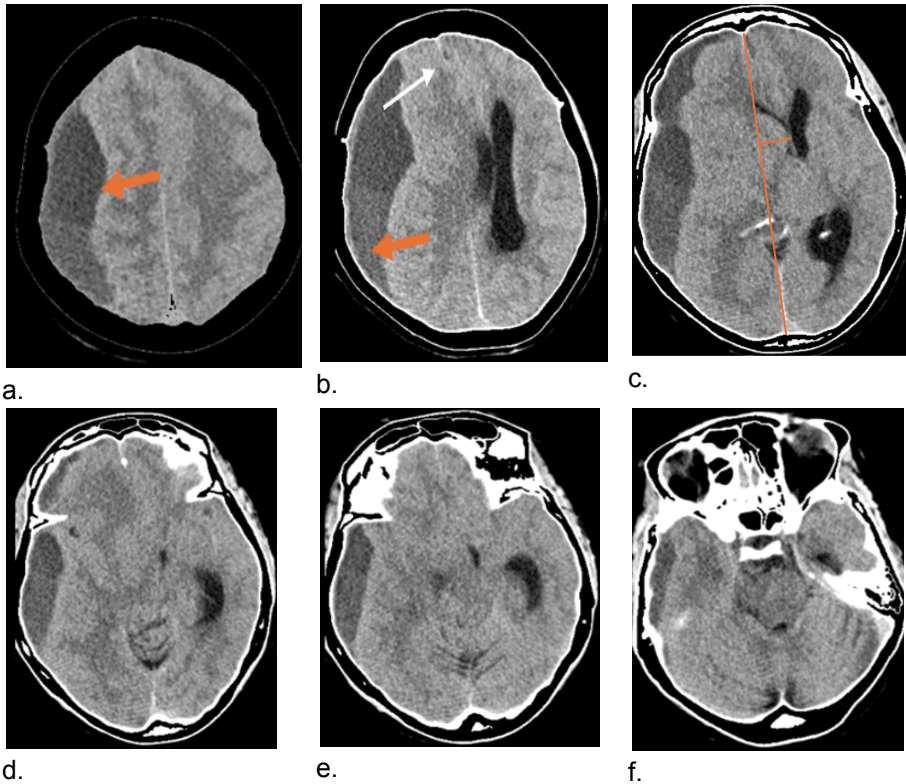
Axial non-contrast CT scan brain window showing a right fronto-parietal subdural collection with mass effect on the right cerebral hemisphere and associated subfalcine herniation (panels a, b, c, d, e, f). A midline shift is present (panel c, 17 mm). The subdural hematoma has a maximum thickness of 34.3 mm at the level of the body of the lateral ventricles (b).
